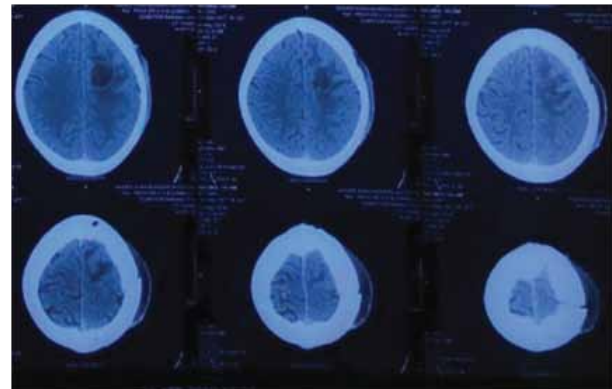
CT-scan of Brain (30 Apr 2019) showing similar findings as fig. 3.1.
